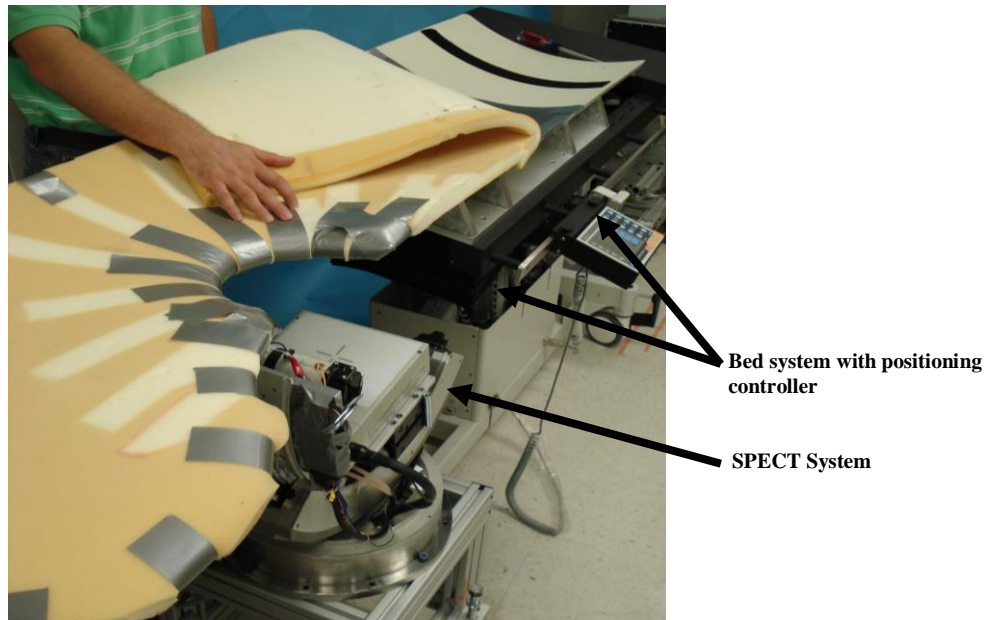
Photograph of an early prototype palette and motorized bed positioning system placed over the SPECT system. The modified patient bed shown in the image has been used for SPECT patient acquisition and will be replaced by the bed design discussed in this paper. The above bed is lined with a $\frac{1}{8}$ " lead shield to reduce emission contamination of the transmission image. Currently, the CT system is unable to traverse around this essentially flat bed due to geometrical constraints.
